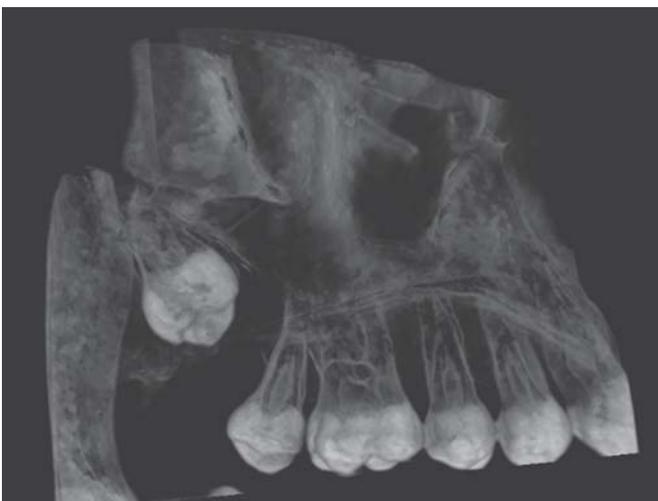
CBCT image (3D palatal view—right side)
